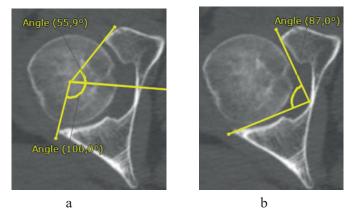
CT image of the pelvis showing measurement of: $a - acetabular sectoral coverage angles (AASA, PASA, HASA); <math>\delta - acetabular sphericity angle (ASpA)$.
